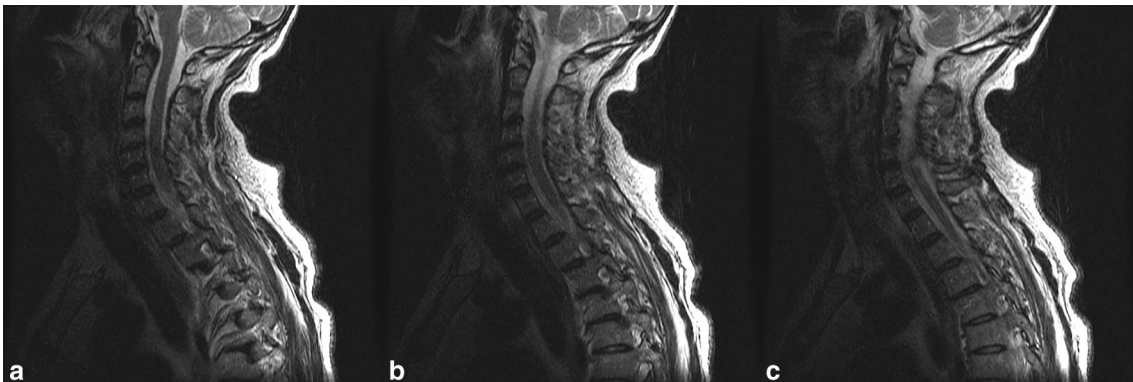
Postoperative sagittal T2 weighted spinal MRI without any compression remaining on the spinal cord
